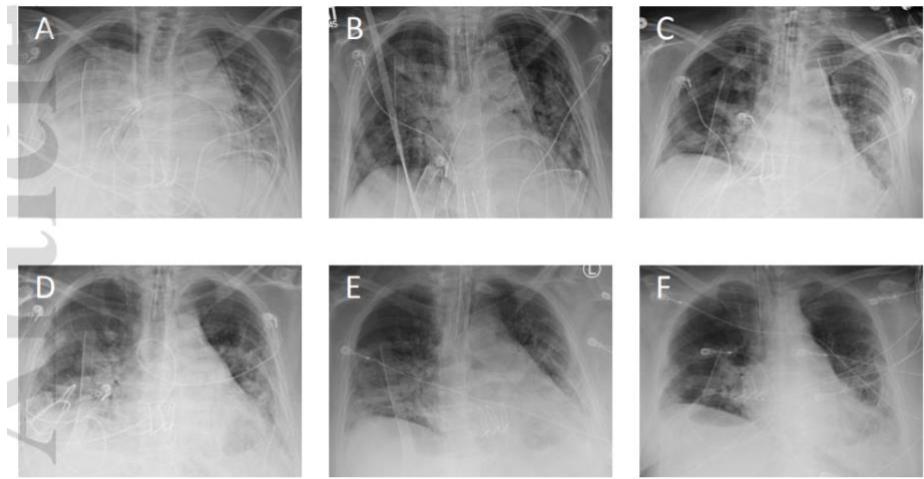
Post-transplant evolution of chest radiographs. Serial post-transplant chest radiographs representing A) PGD on POD1, B) post-intubation for PGD on POD2, C) POD6, D) at time of COVID-19 diagnosis on POD9, E) one day after initiation of chloroquine and azithromycin on POD12, and F) POD17.
